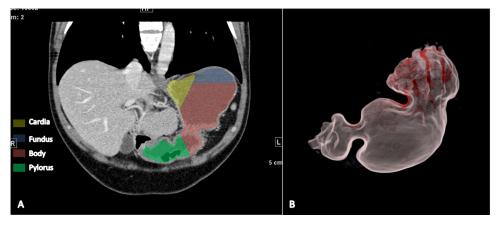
(A) Oblique coronal reconstructed CT image showing various parts of the stomach identified by different color shades. (B) Volume-rendered CT image of the stomach showing the parts. (Color version of figure is available online.)
